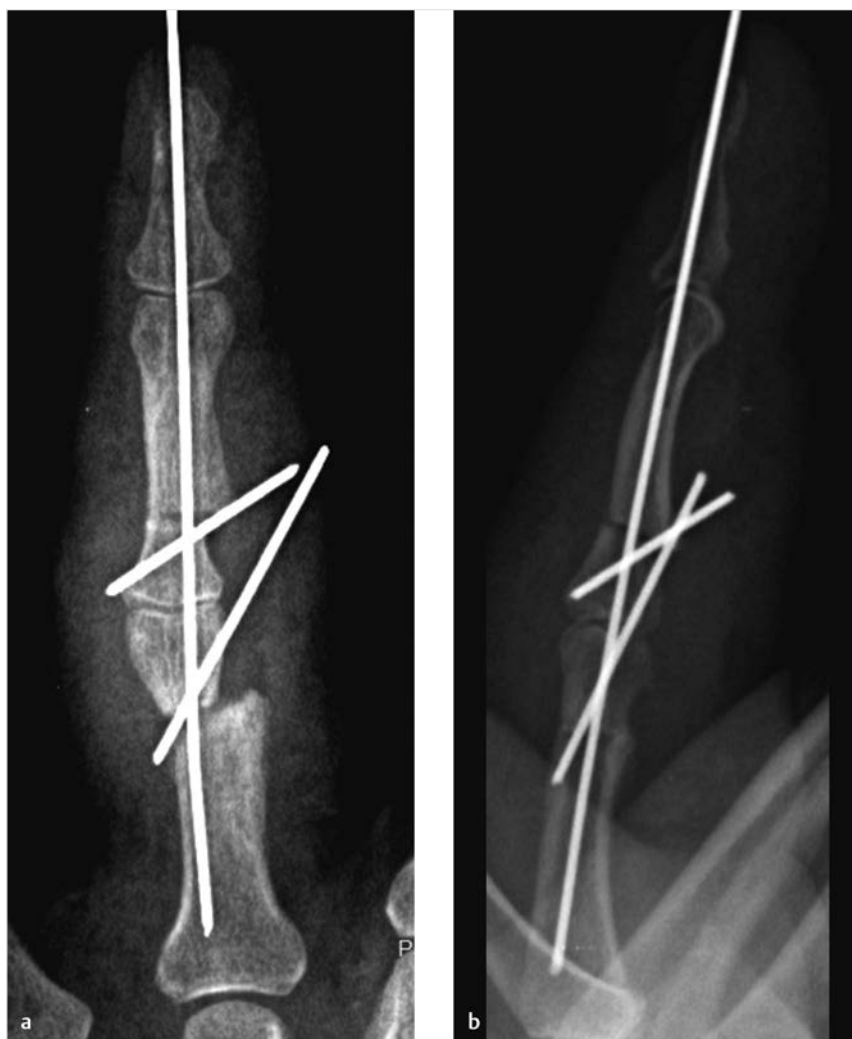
(a, b) Immediate postoperative radiographs with minimum osteosynthesis.
